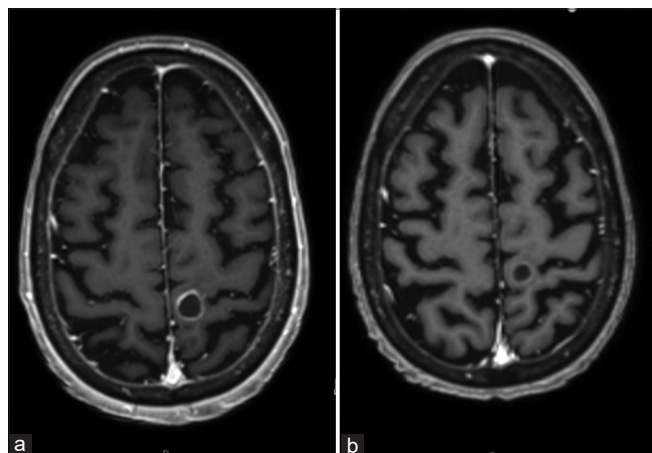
Left precentral gyrus metastatic small cell lung cancer lesion on axial T1-weighted MRI with gadolinium contrast before (a) and 3 months after (b) pulsed reduced dose-rate radiotherapy.
